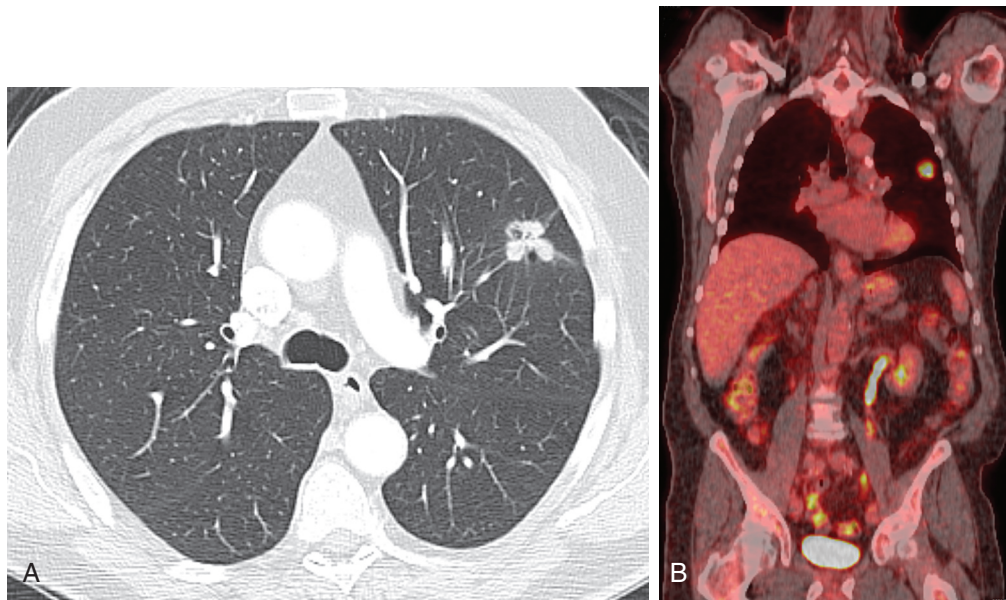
■ Non-small-cell lung cancer. A, Axial computed tomography shows a lobular left upper lobe nodule. B, Fused coronal positron emission tomography–computed tomography shows small nodule in the upper lobe with increased uptake of [^{18}F] fluorodeoxyglucose, consistent with malignancy. Note the absence of nodal and distant metastases.
